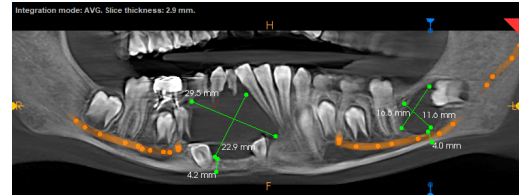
CBCT i mage showing evident multiple Multi nodular radiolucency
